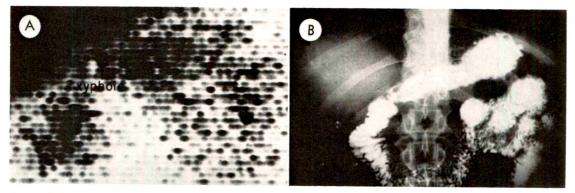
(A) A scan of the pancreas using the technique as described in the text. Immediately following the scan an upper gastrointestinal series was performed and a spot roentgenogram (B) was made. If superimposed, the portion of the scan believed to represent the "head" of the pancreas fits well into the duodenal loop. The body and tail lie behind the greater curvature of the stomach and the loop of jejunum seen in B.
